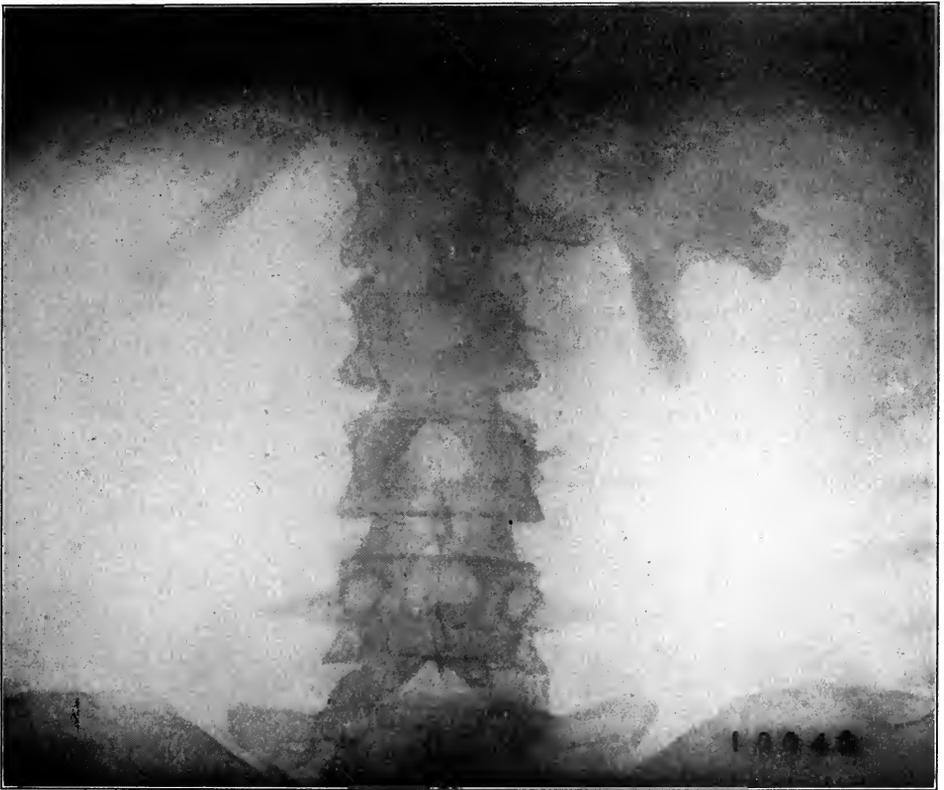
X-RAY PICTURE OF LARGE PHOSPHATIC CALCULI IN THE KIDNEY, X-RAY BY DR. E. W. CALDWELL. (Author's case.)
